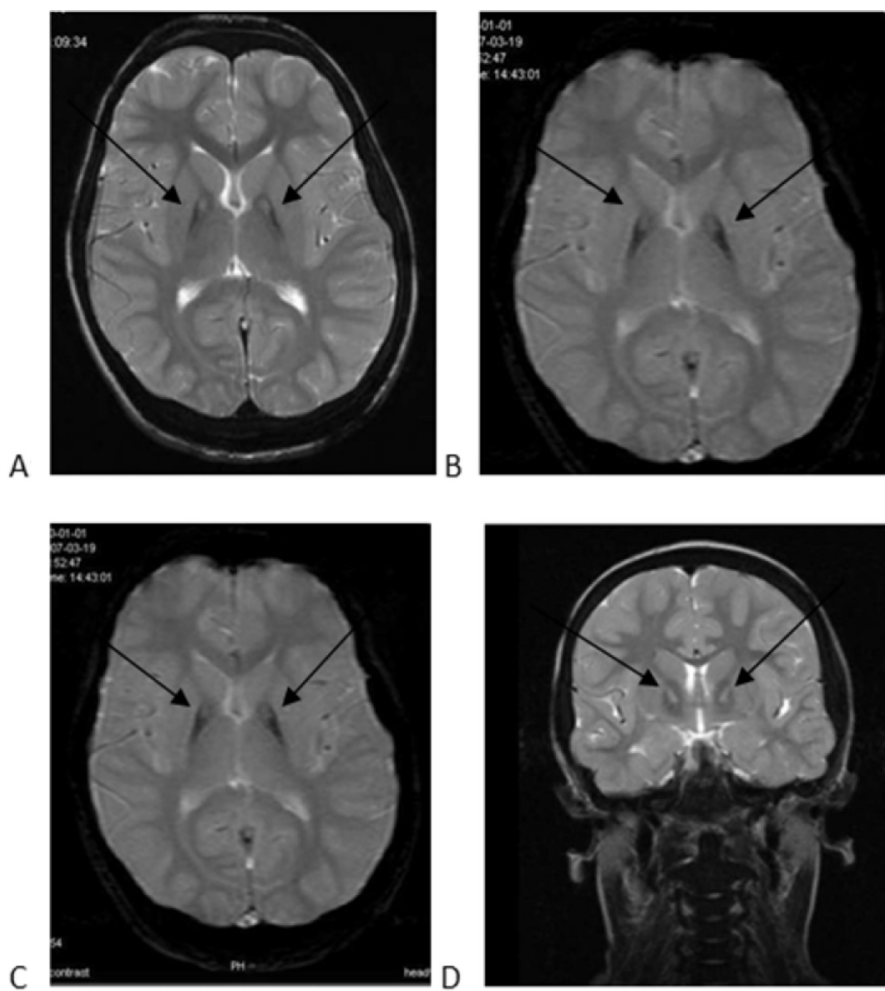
brain MRI, T2-weighted imaging showed the typical “eye of the tiger sign” on both brain hemispheres.
